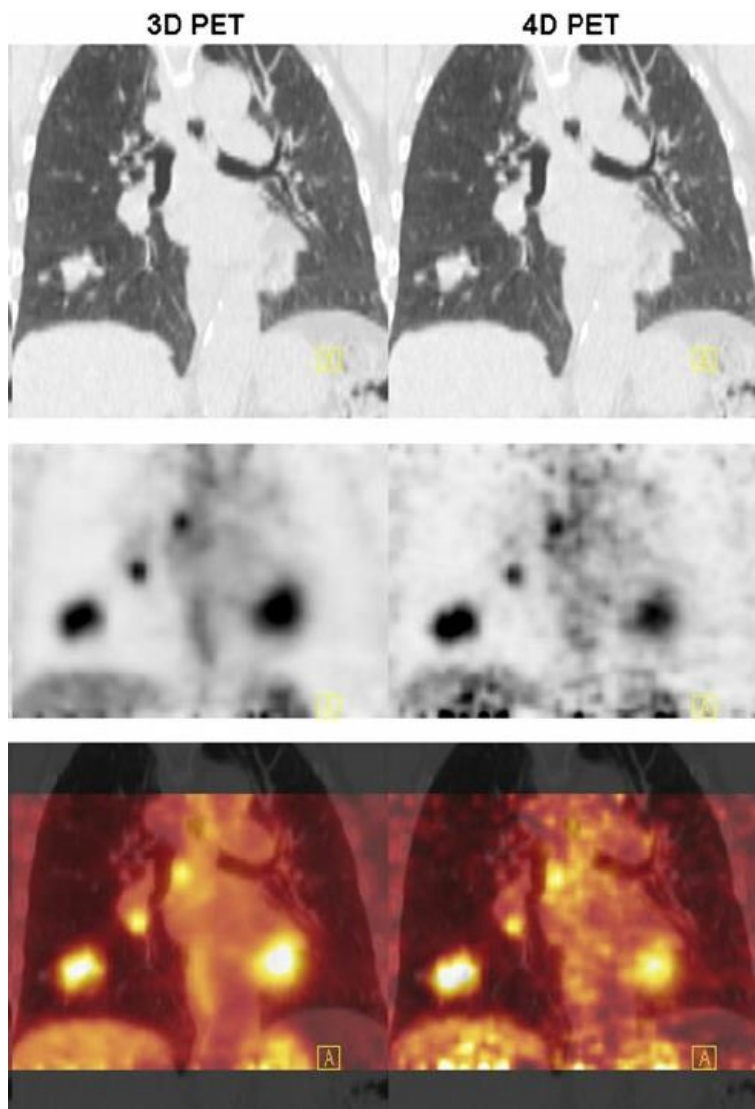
A respiratory compensated (4D) PET/CT acquisition (right) and a regular 3D PET/CT acquisition (left). CT images (top), PET images (middle) and coregistered PET/CT images (bottom), demonstrating the effect of breathing motion on Tumor delineation. On the motion-compensated PET/CT it is observed that lesions are easier to identify, mostly due to the higher contrast in this image [76].
